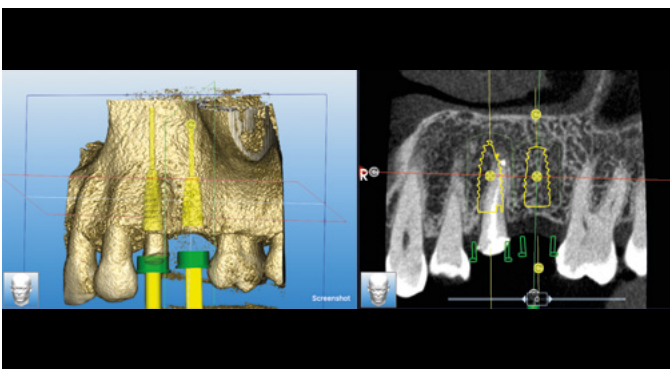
CT scan and digital planning for implant placement
